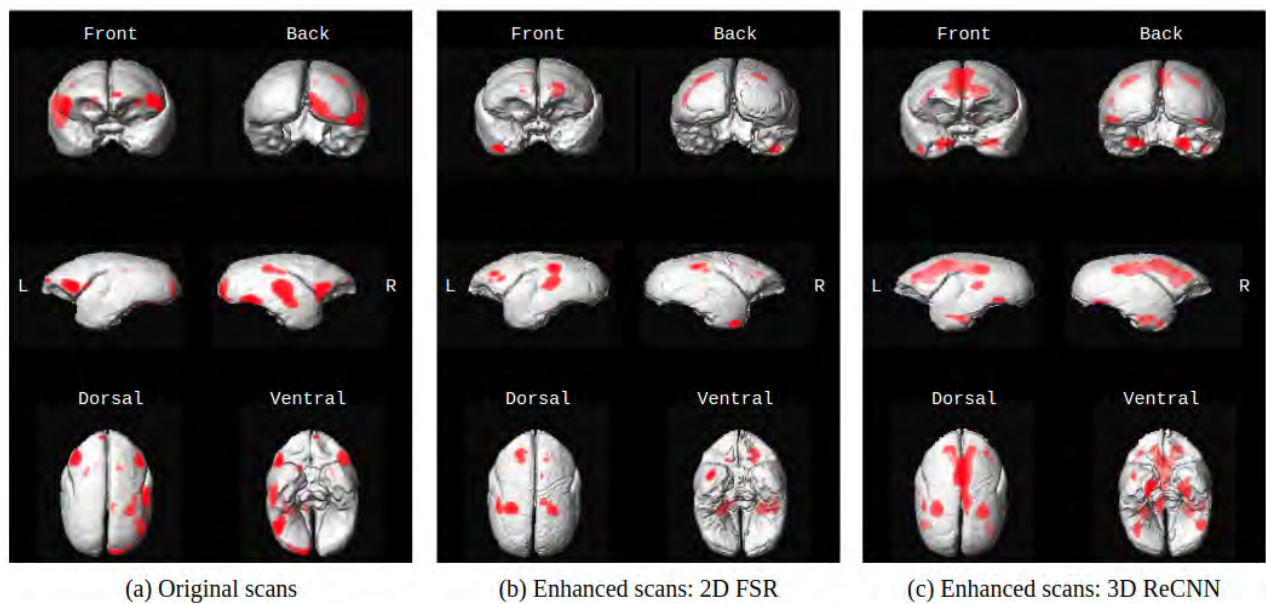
VBM analysis of GM decrease for 90 MRI scans from 24 marmosets during in their late adulthood period with age greater than 8 years using smwGM segmentation from (a) original scans, (b) enhanced scans by 2D FSR, and (c) enhanced scans by 3D ReCNN. Darker shades of red represent a more significant decrease in a specific region than lighter shades.
